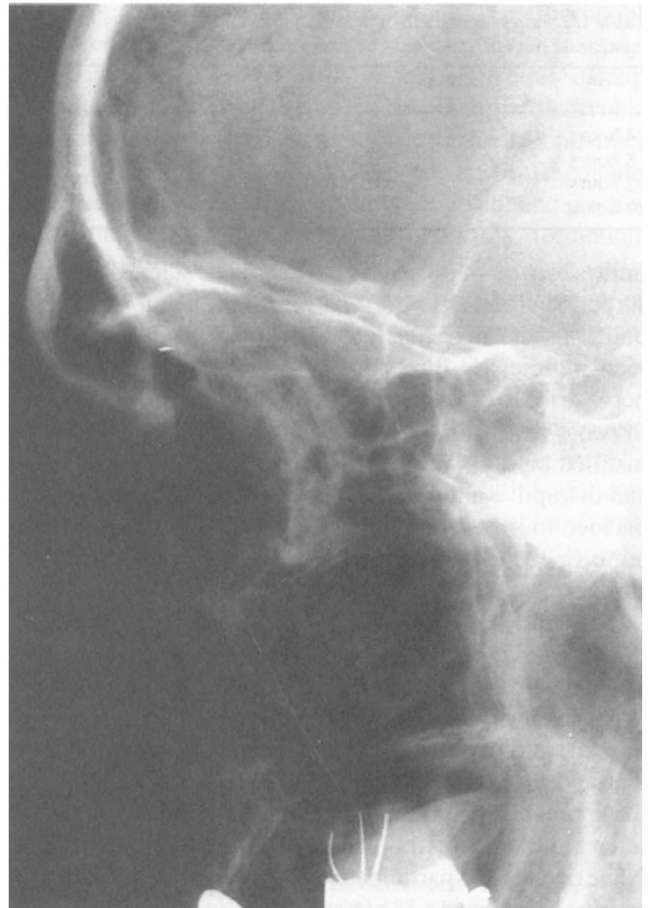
Skull radiograph showing the metallic foreign body in the orbit.*
